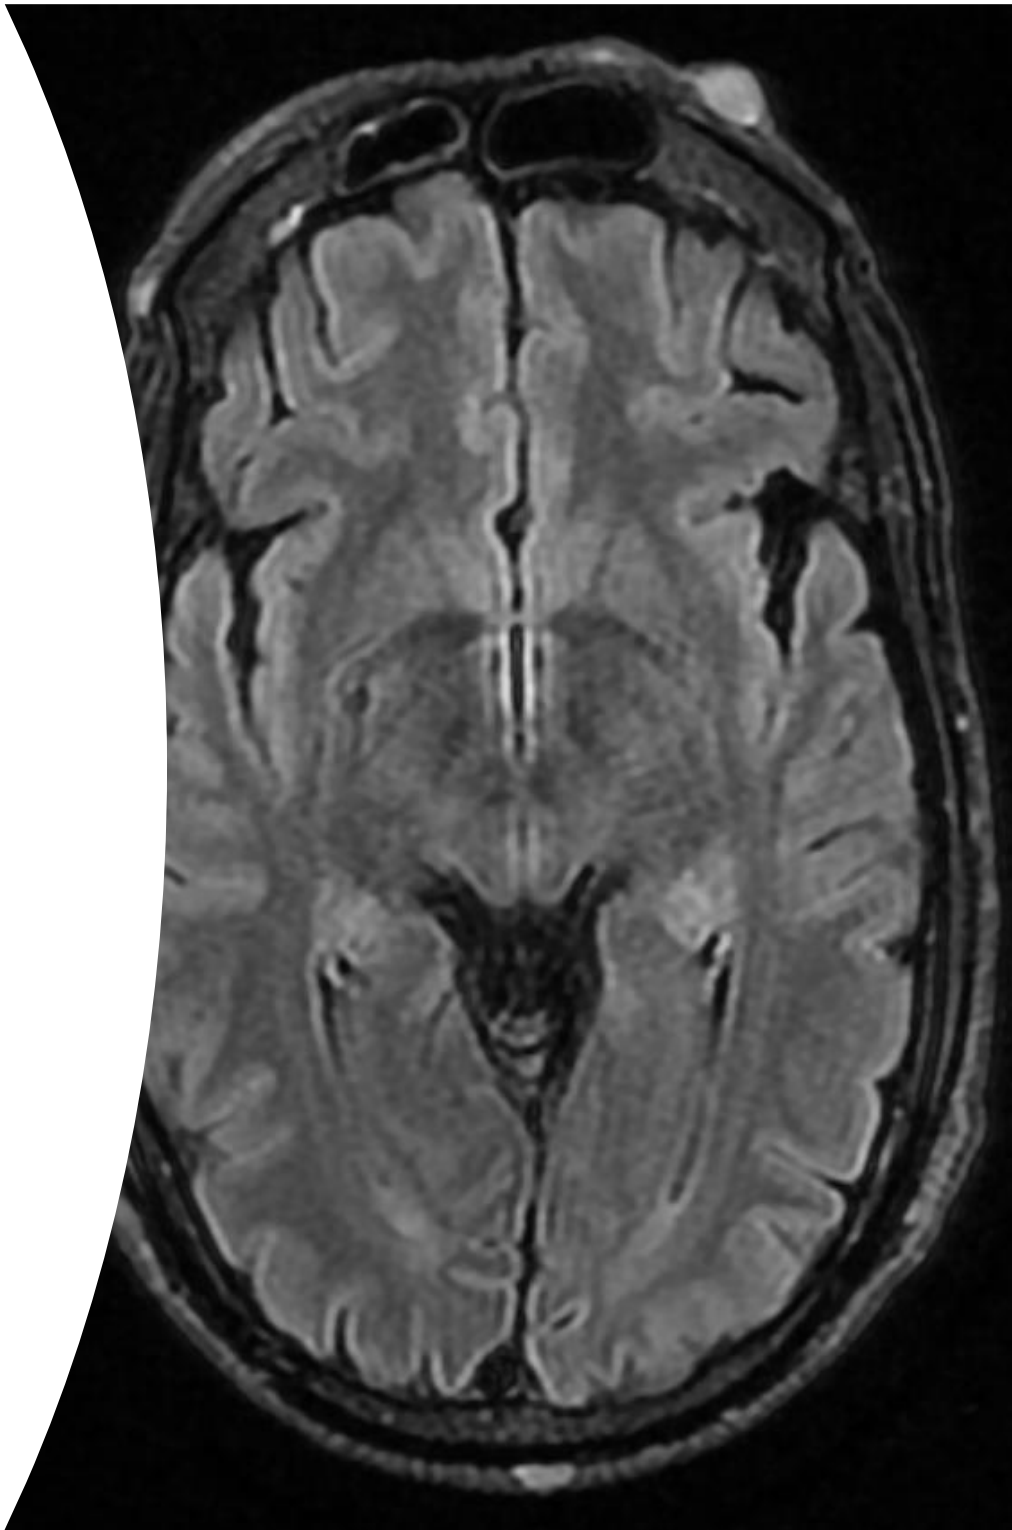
Axial FLAIR MRI of the brain demonstrating multiple subcutaneous scalp neurofibromas, with no focal intracranial parenchymal abnormality identified. The case report describes these lesions as T1-isointense and T2/FLAIR-hyperintense.
